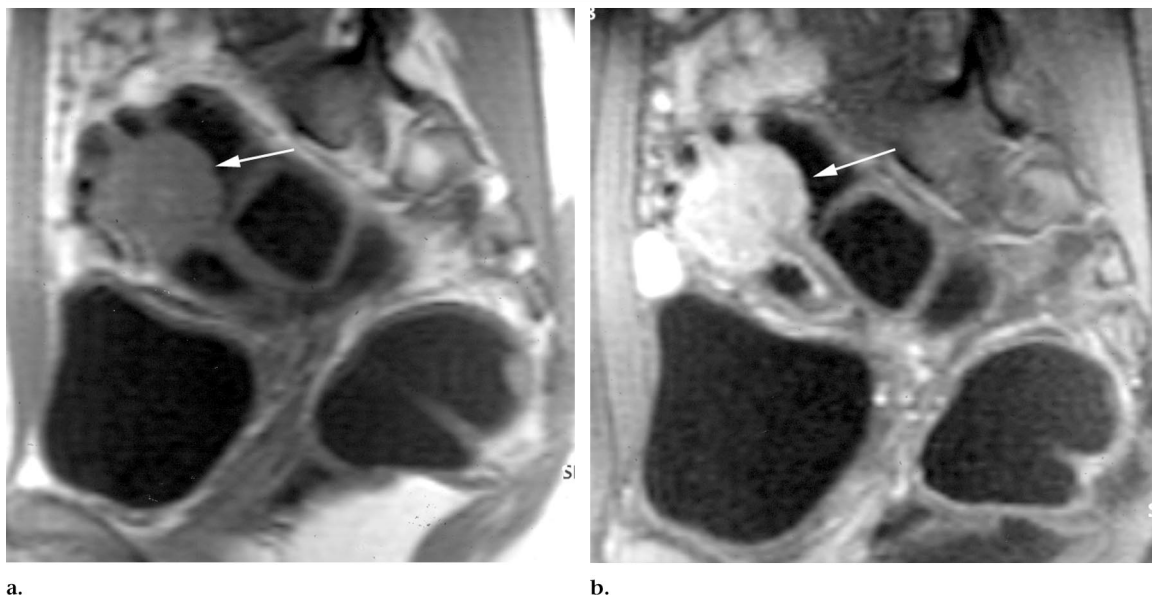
Sagittal T1-weighted fast low-angle shot MR image (100/13; flip angle, 65°) obtained after rectal enema (a) before and (b) after intravenous injection of gadolinium-based contrast material demonstrates large fibrotic nodule (arrow) in inferior part of sigmoid colon. True-positive diagnosis of sigmoid colon involvement with endometriosis was determined at MR imaging.
